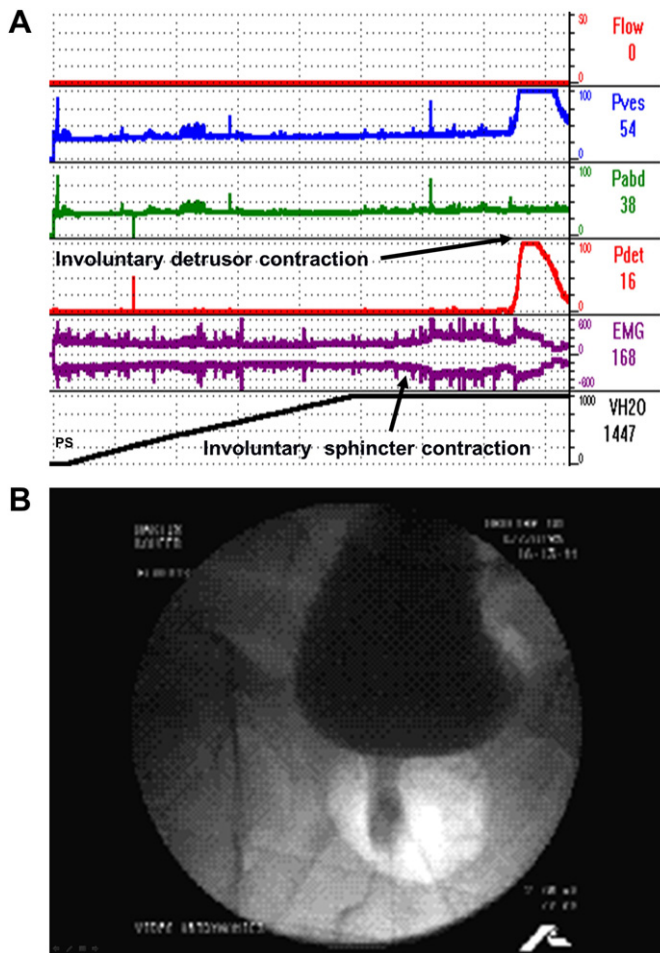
Detrusor-external sphincter dyssynergia (DESD). A. Urodynamic study demonstrating classic findings of DESD. An involuntary sphincter contraction precedes and continues throughout most of the involuntary detrusor contraction. B. X-ray obtained at the height of the detrusor contraction showing complete obstruction at the membranous urethra due to the sphincter contraction. Transurethral resection of the prostate is of no help in such a patient. Optimal treatment is aimed at abolishing the involuntary detrusor contractions and instituting intermittent self-catheterization.
